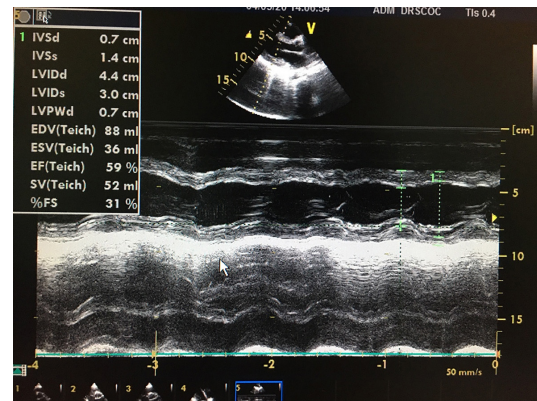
Decreased systolic functions in echocardiography of the patient
